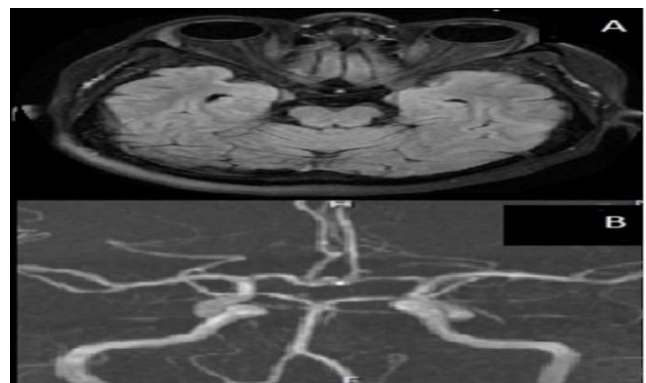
Cranial magnetic resonance imaging (A) and magnetic resonance angiography (B) image is normal
